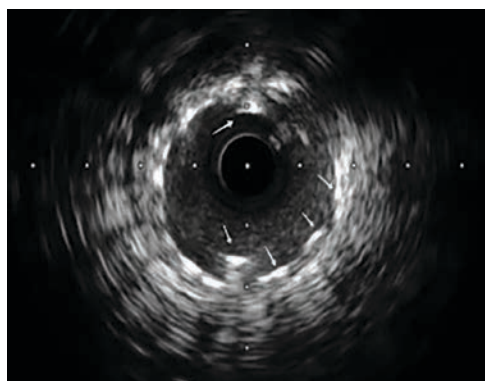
Intravascular ultrasound (IVUS) showing wire loop near proximal LAD (white arrows).
